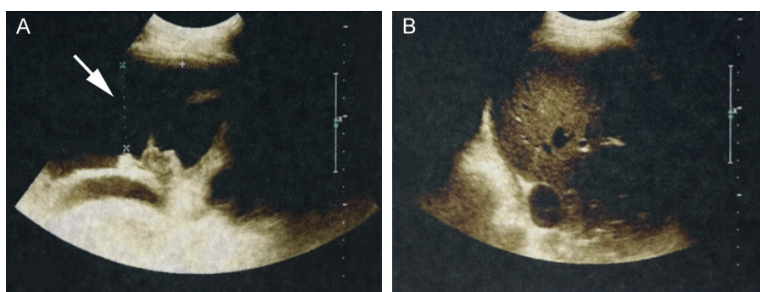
Chest ultrasonography of the patient. A. Chest ultrasonography showed an opaque dark area of fluid of 9.3 cm in the left-sided thoracic cavity (white arrow). B. Chest ultrasonography showed no fluid in the right-sided thoracic cavity.
